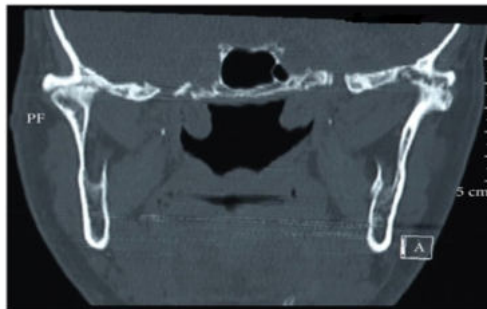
Coronal section of computed tomography
